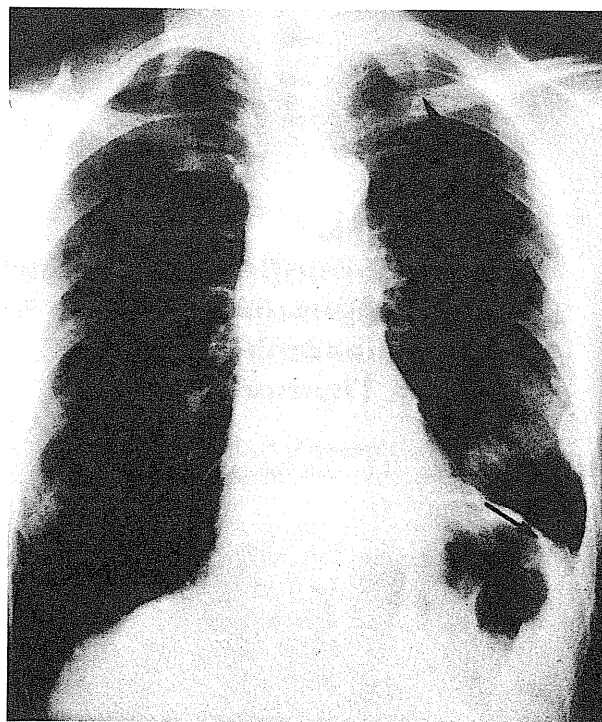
Chest radiograph showing multiple lesions (arrowheads) in the left lung field and slight pleural effusion (arrow).
